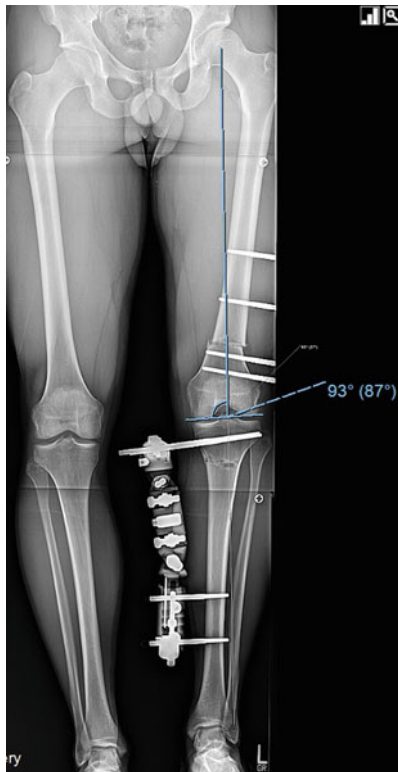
The radiograph shows an acute correction of the femoral deformity with an LDFA of 87° . The tibia must now be corrected to an MPTA of 87° as well
